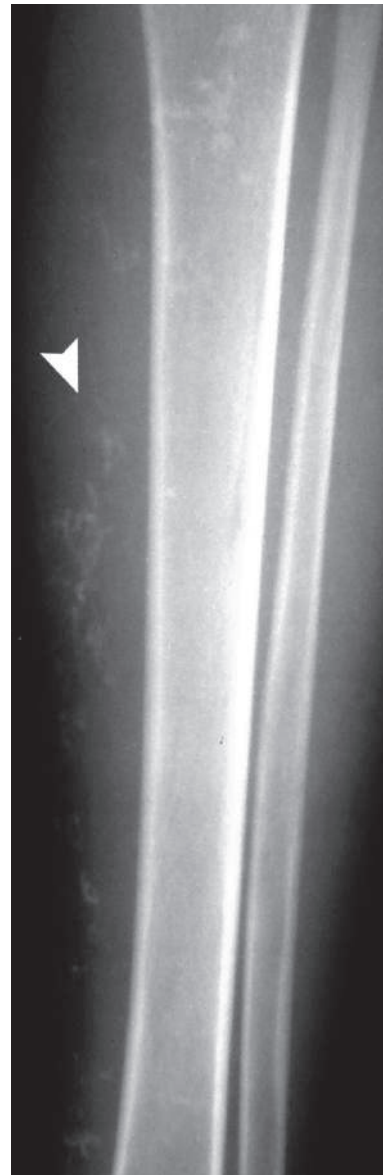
Anteroposterior plain radiograph of the left leg shows multiple fine soft tissue calcifications in a patient with dermatomyositis (*arrowhead*)
